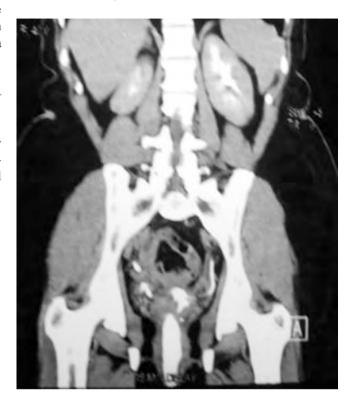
CT image showing vesico vaginal fistula
